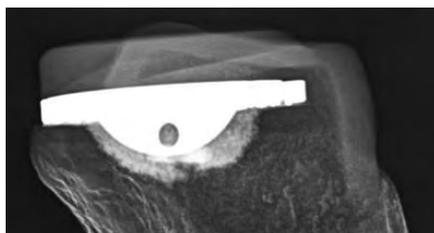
X-ray image of figure 4a
